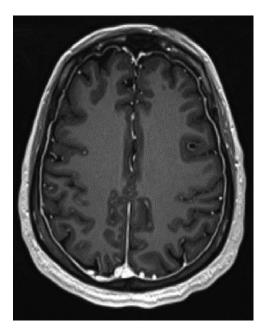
Axial section of brain MRI with contrast showing diffuse dural enhancement.
